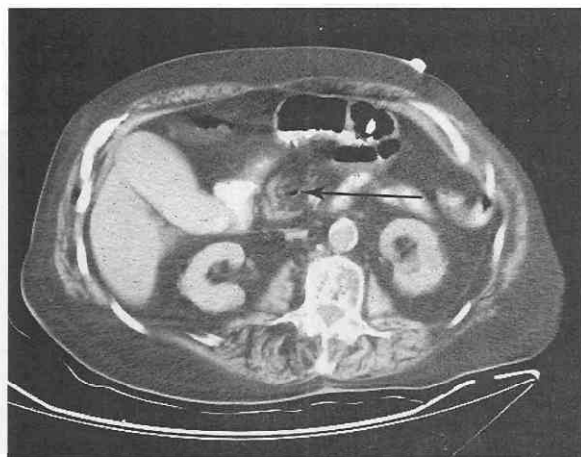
CT scan of peripancreatic region shows a small collection of gas in the superior mesenteric vein (arrow). This was secondary to a perforated diverticulum in the small bowel that had tracked into the vein.
